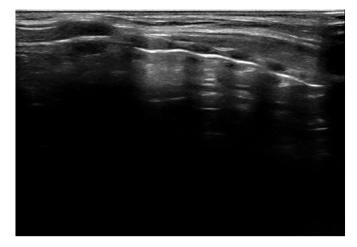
Sonographic appearance of the tracheal rings.
